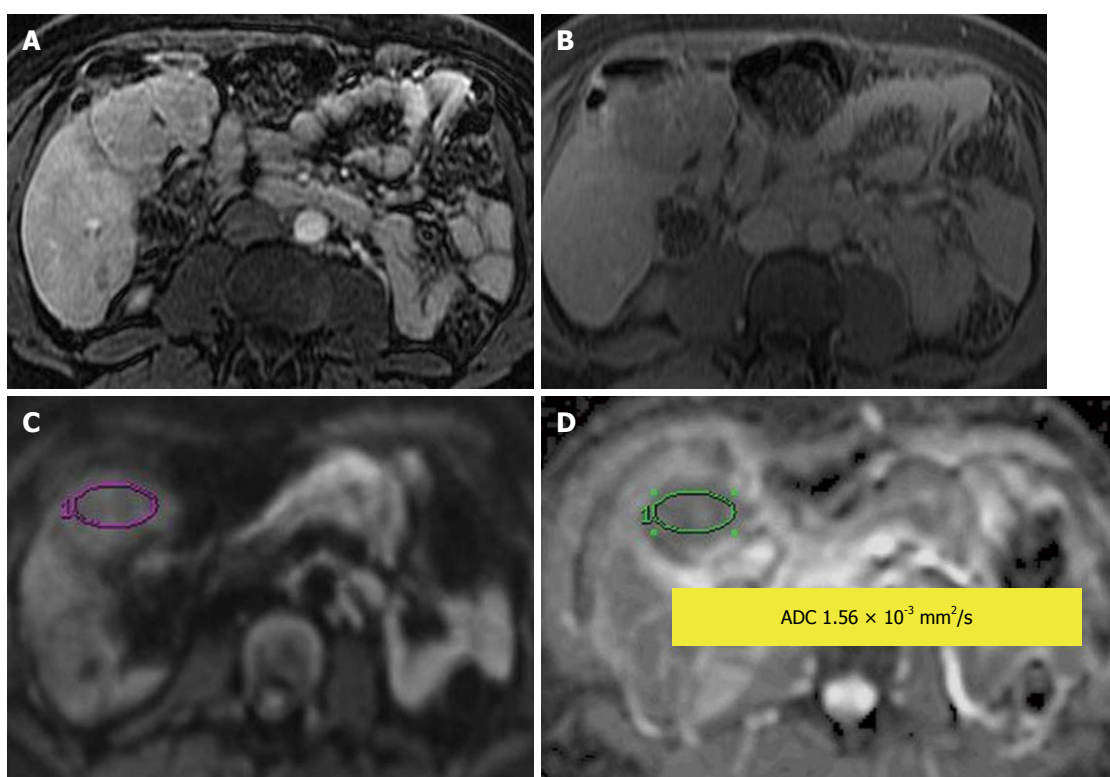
Hepatocellular adenoma. A: Contrast-enhanced T1-weighted gradient recalled-echo in arterial phase; B: Delayed post contrast phase; C: Diffusion-weighted image; D: Apparent diffusion coefficient (ADC) map. An arterial enhancing lesion with delayed wash out is visible; it demonstrates impeded diffusion with $ADC = 1.56 \times 10^{-3} \text{ mm}^2/\text{s}$.
